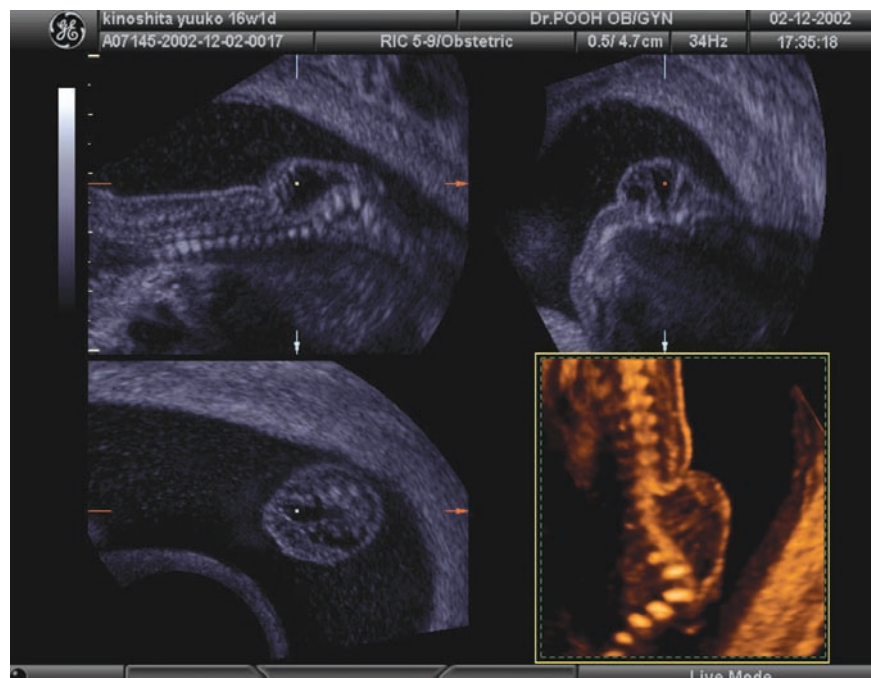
Three-dimensional ultrasound image of myelomeningocele with kyphosis at 16 weeks of gestation. Three orthogonal views and surface reconstruction image. (Upper left) Sagittal ultrasound image. Spinal cord completely protrudes into the sac surface from spinal canal and severe kyphosis is seen (upper right). Axial ultrasound view. (Lower left) Coronal ultrasound view of myelomeningocele. Lower right figure demonstrates the sagittal vertebral bony structure by 3D thick slice.
